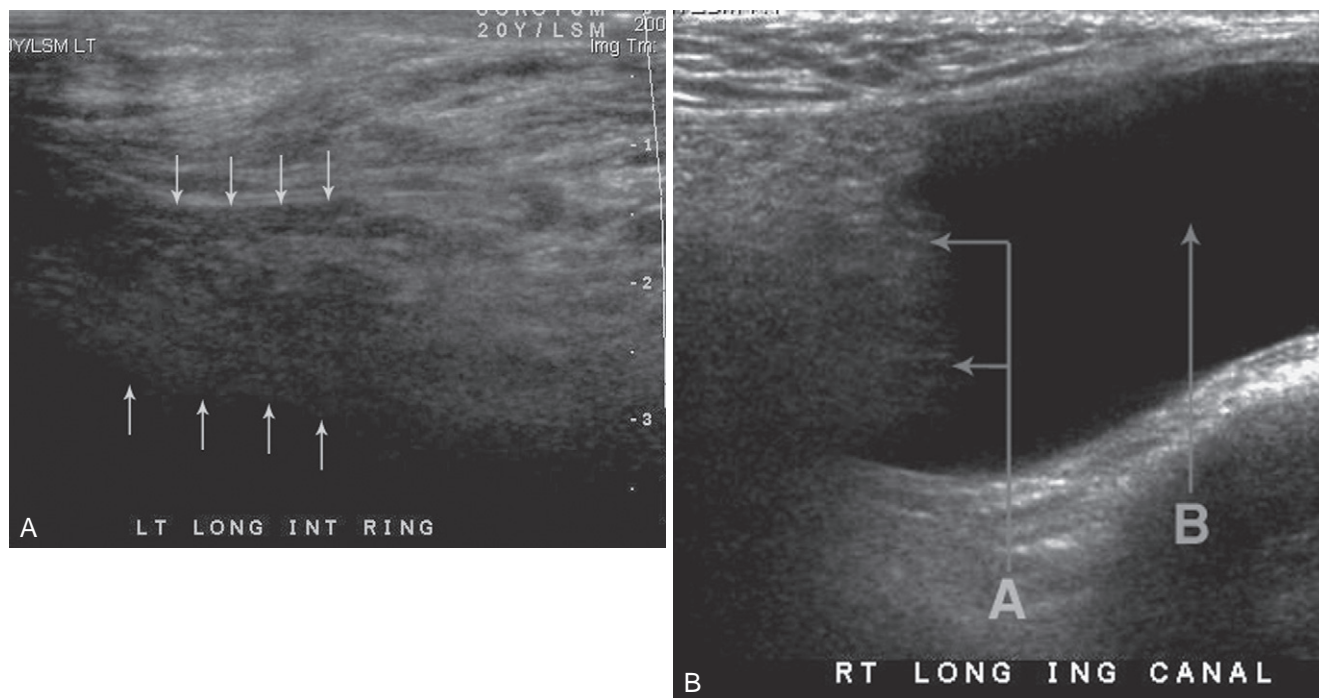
Ultrasound examination of the inguinal canal. A, No hernia. The arrows outline the normal inguinal canal. The strands are the vas deferens and cord structures. Using Doppler imaging, signals to the scrotum and venous signals to the IVC would be seen. B, Inguinal hernia. The double arrow points to the leading edge of incarcerated viscera. If it were bowel, peristalsis would be evident; if it were omentum, it would not. The single arrow is fluid in the hernia sac.
